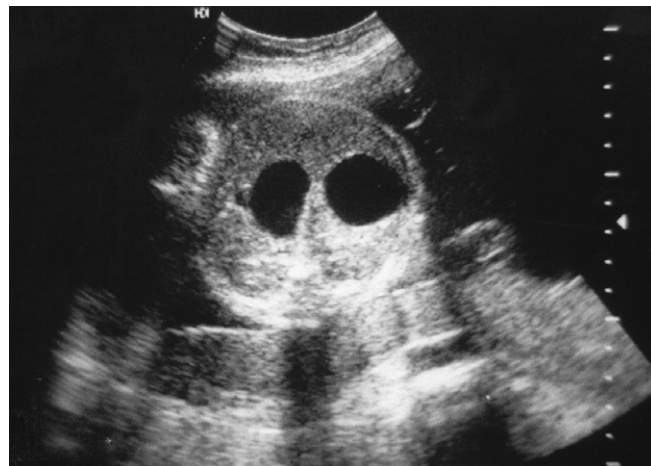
Fetal ultrasound with “double-bubble” sign.
